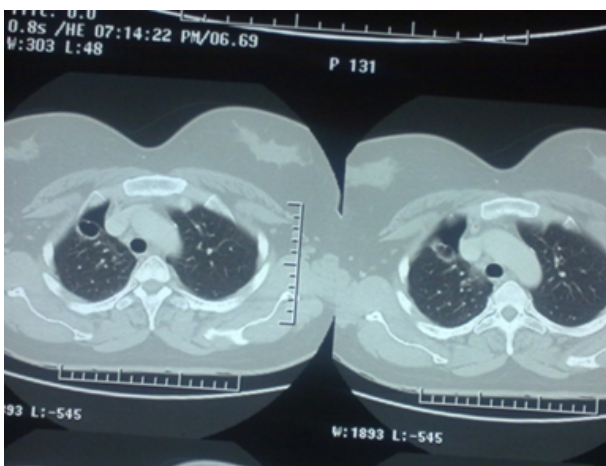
CT scan chest with sub pleural bullae in right upper and mid zone.
